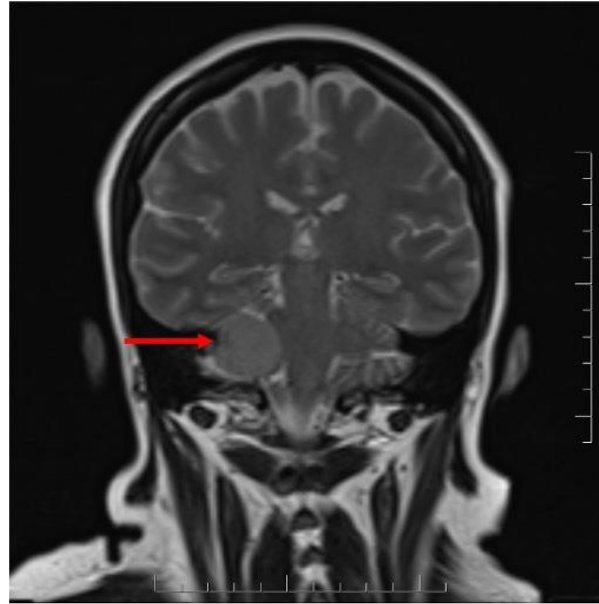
Magnetic resonance imaging of the patient showing the cerebellopontine tumour (marked by red arrow).
